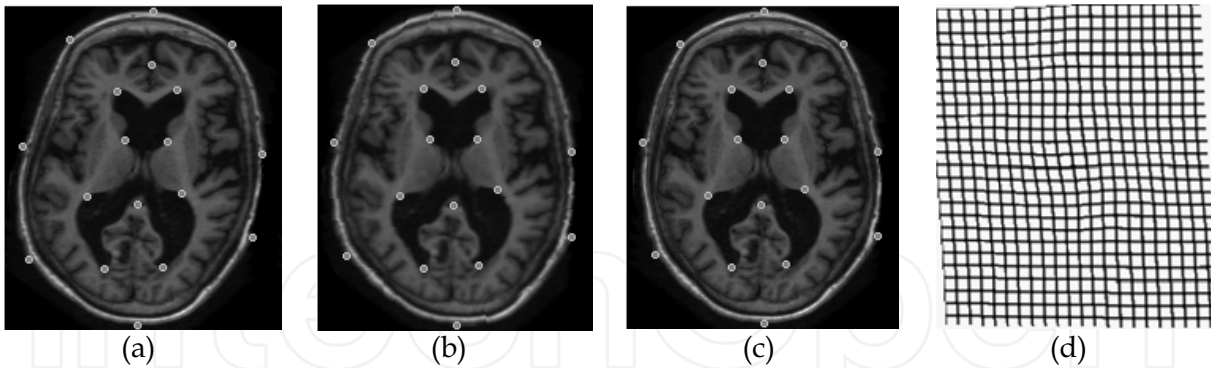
Example of MRI image registration with fuzzy kernel regression affine transformations composition. Input image (a), registered image (b) and target image (c). Deformed grid in (d). In this example 18 landmark points were used.
